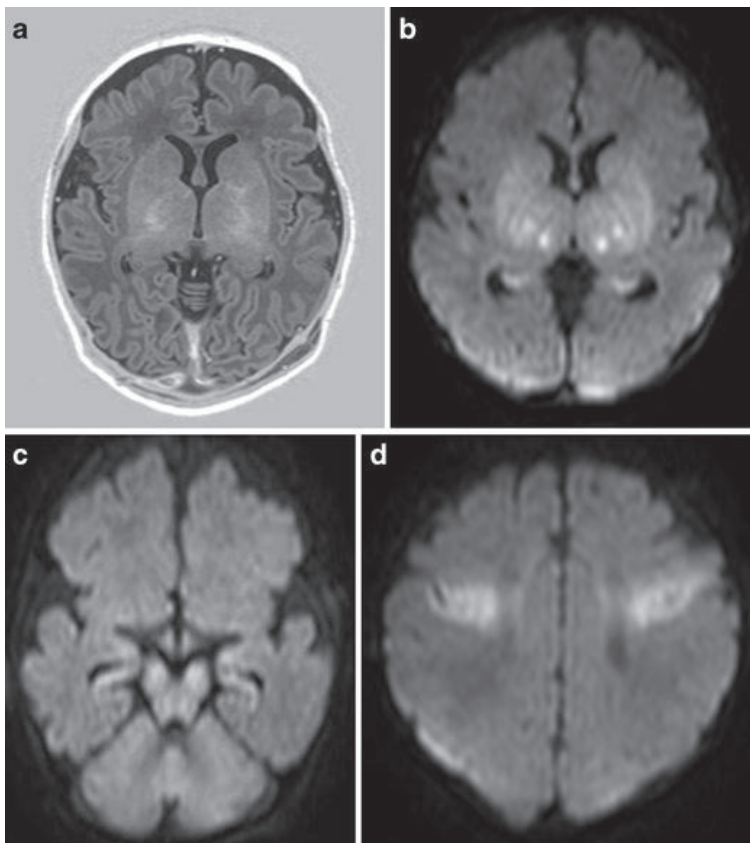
MRI images of a full-term infant after an acute, severe hypoxic-ischemic event. The MRI pattern is suggestive of acute near total asphyxia: a Inversion recovery sequence (TR 5038/TE 30/TI 600) does not show a normal signal within the posterior limb of the internal capsule, but areas of increased signal intensity within thalami and basal ganglia. DWI (b–d) shows restricted diffusion in the ventrolateral thalami, lentiform nuclei, cerebral peduncles, and in the perirolandic cortex. Also note involvement of the hippocampi.
